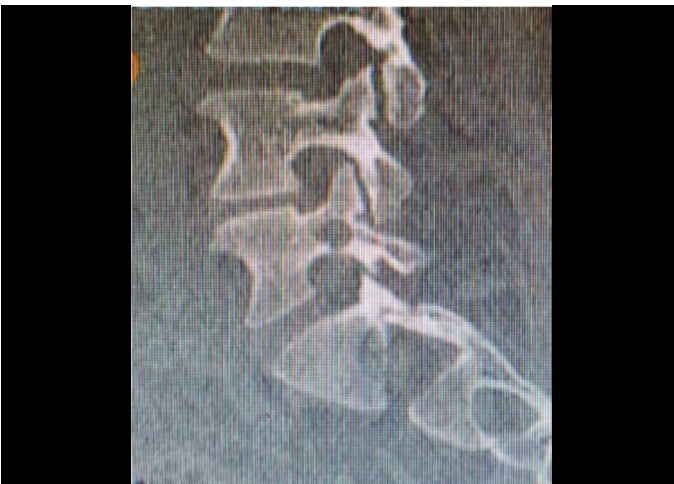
The sagittal cut of the postoperative CT is used to evaluate the bony tunnel in the right pedicle of L5.
